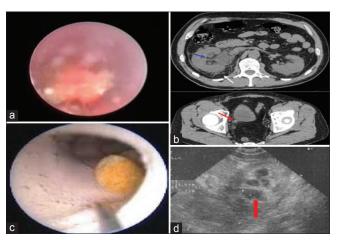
(a) Ureteroscopic image showing turbid infected urine after dislodging the stone, (b) Plain computed tomography kidneys, ureters, and bladder showing perinephric stranding with dilatation of right ureter with distal ureteric stone impaction, (c) Ureteroscopic image showing dislodged stone in the control group, and (d) Floating debris on ultrasonography
